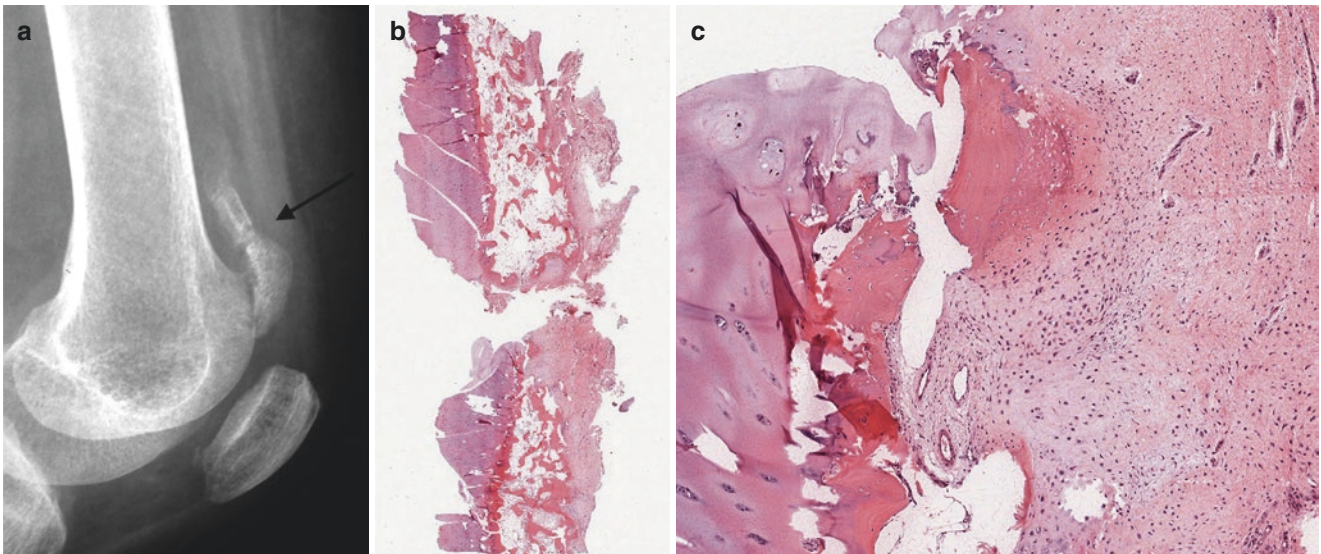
Avulsive fracture of a mineralized tendon insertion segment. (a) Radiograph showing fracture of the ossified tendon end (*arrow*). (b) Panoramic microphotograph of both ends of the fracture fragments. (c) Reactive fibro-chondro-osteoid proliferation
